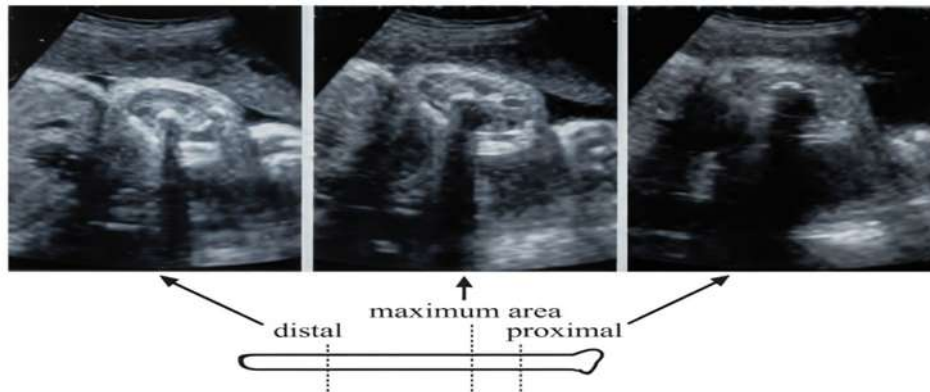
Standard sonographic measurement of fetal thigh circumference
